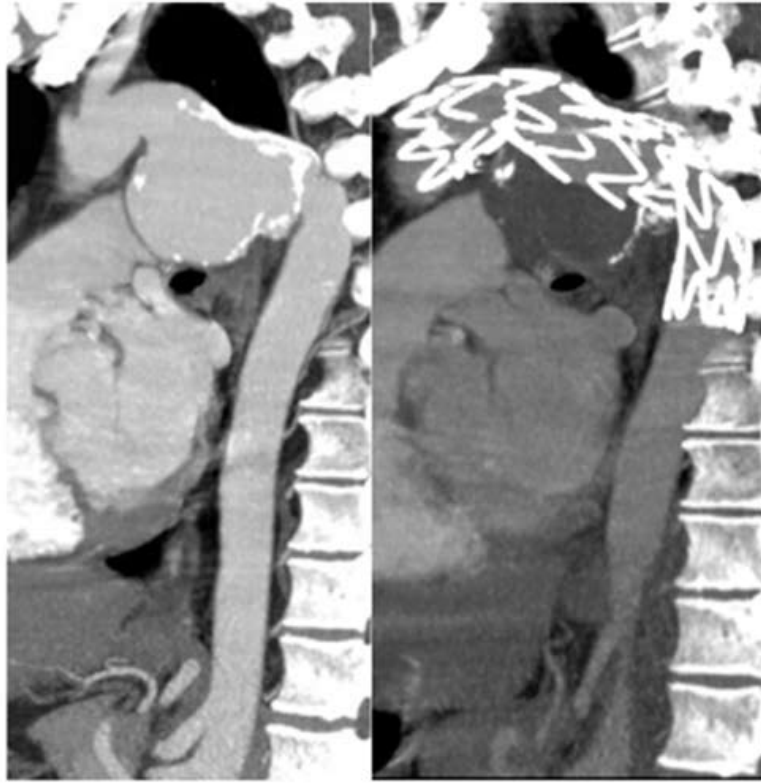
Computed tomography - CT - with intravenous contrast agent administration. Figure shows thoracic aortic aneurysm on the left panel and aortic remodelling induced by stent-graft apposition on the right panel.
